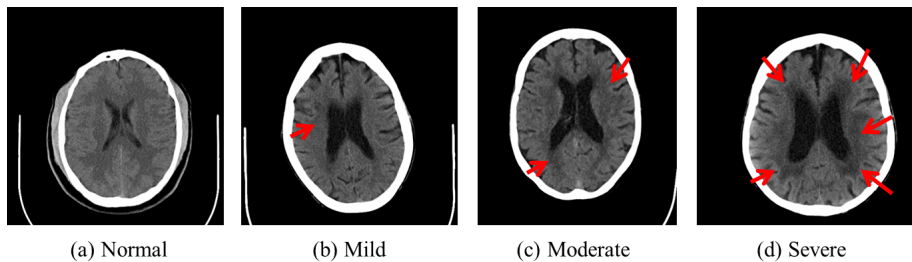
Examples of CT images of the brain: (a) normal brain appearance, (b) brain with mild cerebral SVD, (c) brain with moderate SVD, and (d) cerebrum with severe SVD. The red arrows point out where the lesions are.
